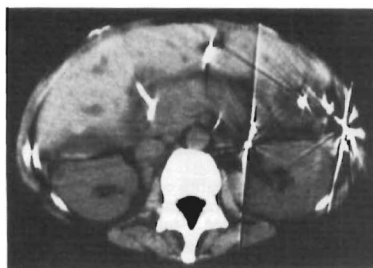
Computed tomogram of Case 4 on the posttransplant d 8. The entire pancreas is swollen.
